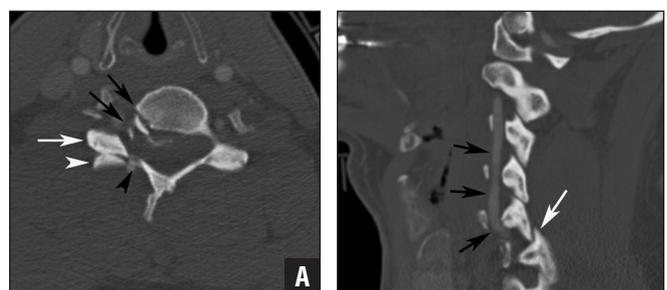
Computed tomography imaging of C5-6 pedicolaminar fracture-dislocation. Axial image through the level of C5-6 showing fractures through the right C5 lamina (black arrowhead), pedicle, and posterolateral margin of the body (black arrows), resulting in a free-floating articular mass. Note the reversed relationship of the inferior C5 (white arrow) and superior C6 (white arrowhead) articular facets due to interfacetal dislocation (A). Sagittal 2-dimensional reconstruction through the right-sided facet joints showing the unilateral interfacetal dislocation (white arrow) and intact but deviated right vertebral artery (black arrows) (B).
